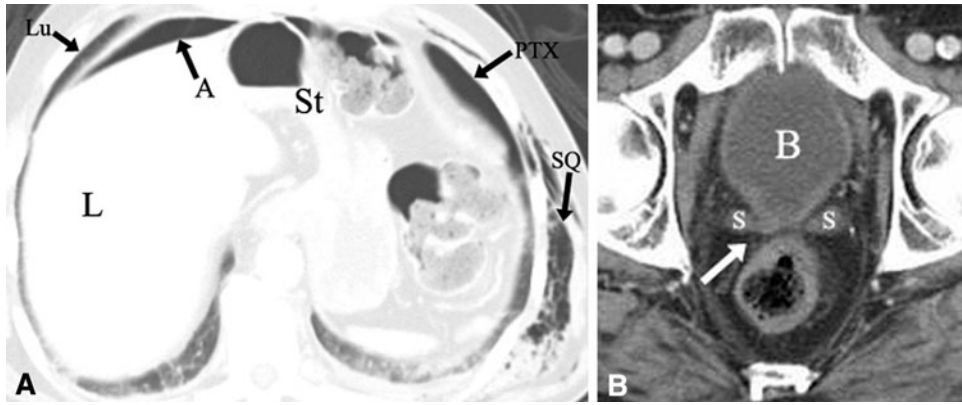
A 70-year-old male status post-blunt abdominal trauma. A Axial CT of the lower chest in a lung window demonstrated a small amount of free air (*A*) anterior to the liver (*L*) and posterior to the lung (*Lu*). Left pneumothorax (*PTX*), subcutaneous emphysema (*SQ*), and stomach (*St*)
